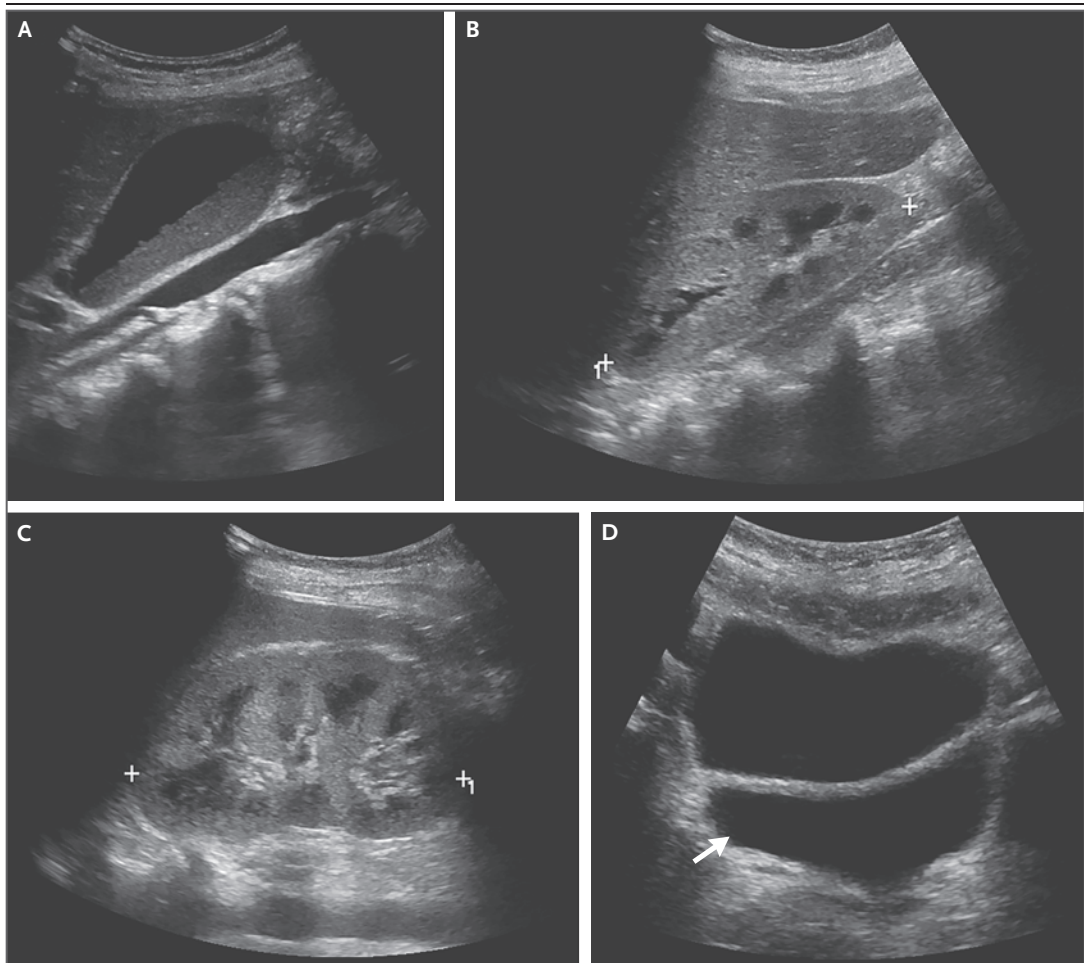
Abdominal Ultrasound Images.
